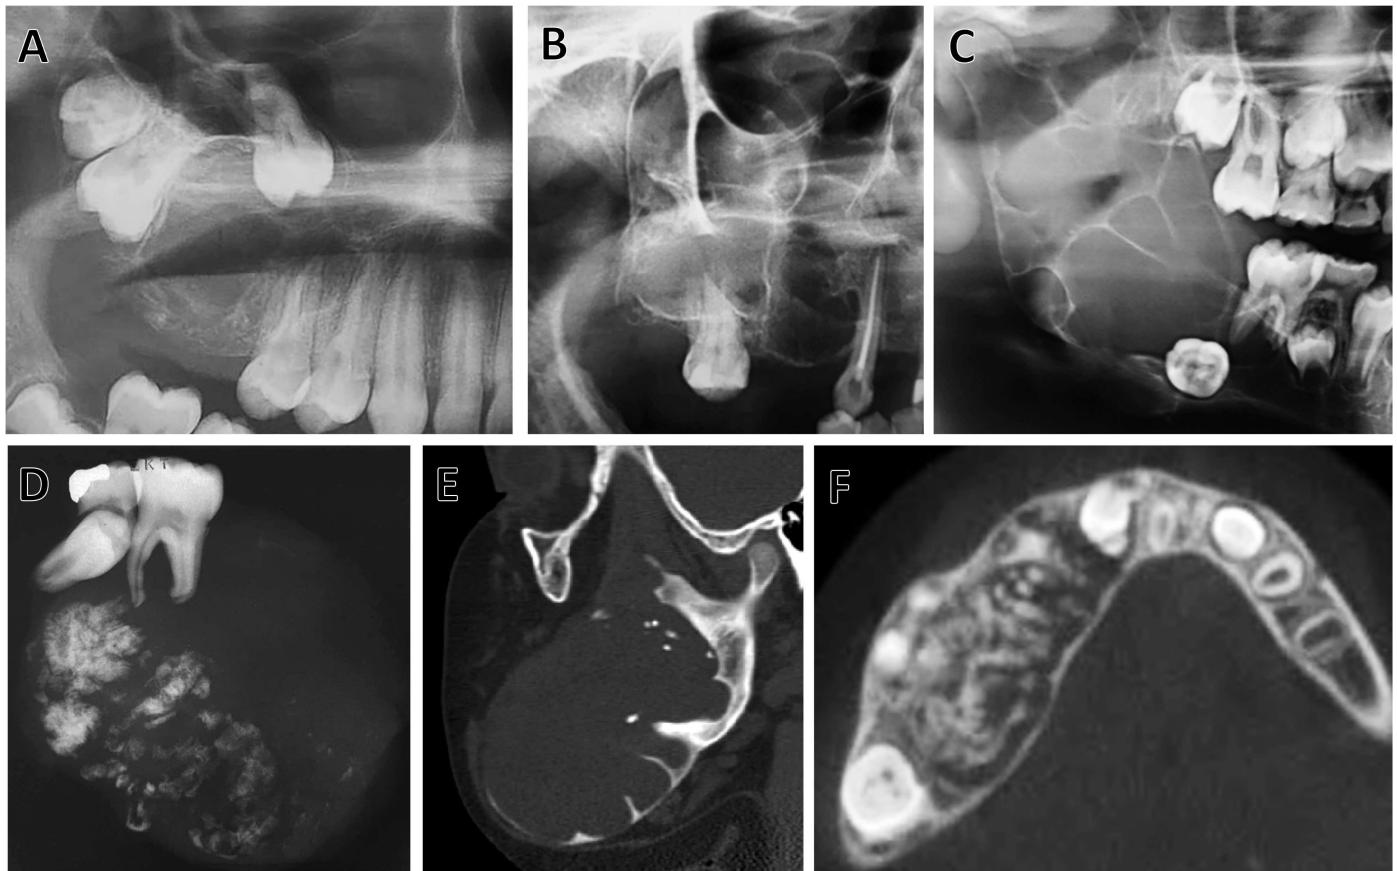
Radiographic features of AF and AFD/AFO. A-C. AF commonly presented as well-defined multilocular radiolucencies associated with unerupted molars, causing cortical bone expansion and root resorption. D-F. AFD/AFO were aggressive tumors showing varying amounts of radiopaque foci within the lesions and exuberant sizes.
